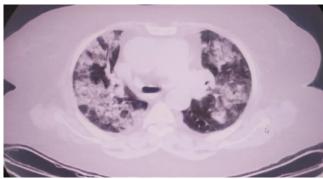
Bilateral diffuse central and ground glass density infiltrates on thorax CT imaging
